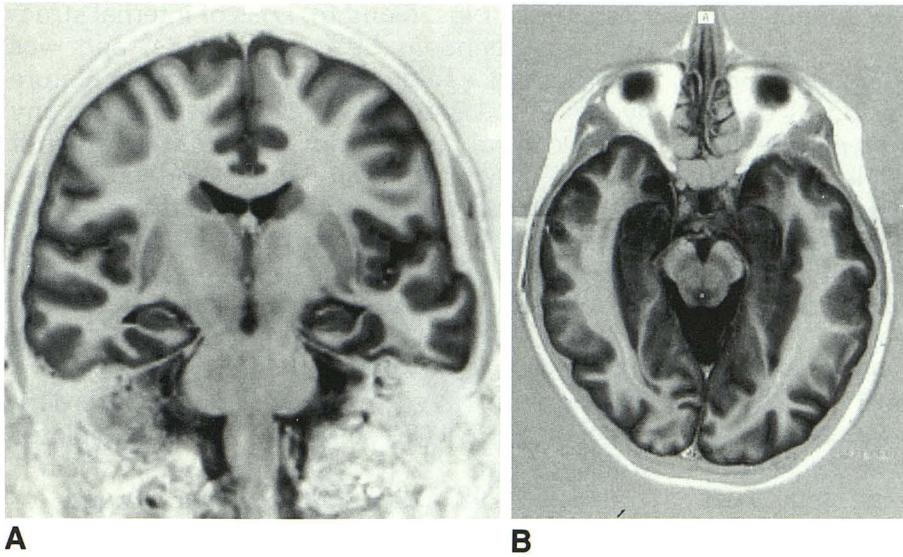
The normal anatomy of the hippocampus is shown in these tilted coronal and axial T1-weighted inversion-recovery images (3500/26; inversion time, 300 ms). In all figures, the patient's left is on the right side of the image.
